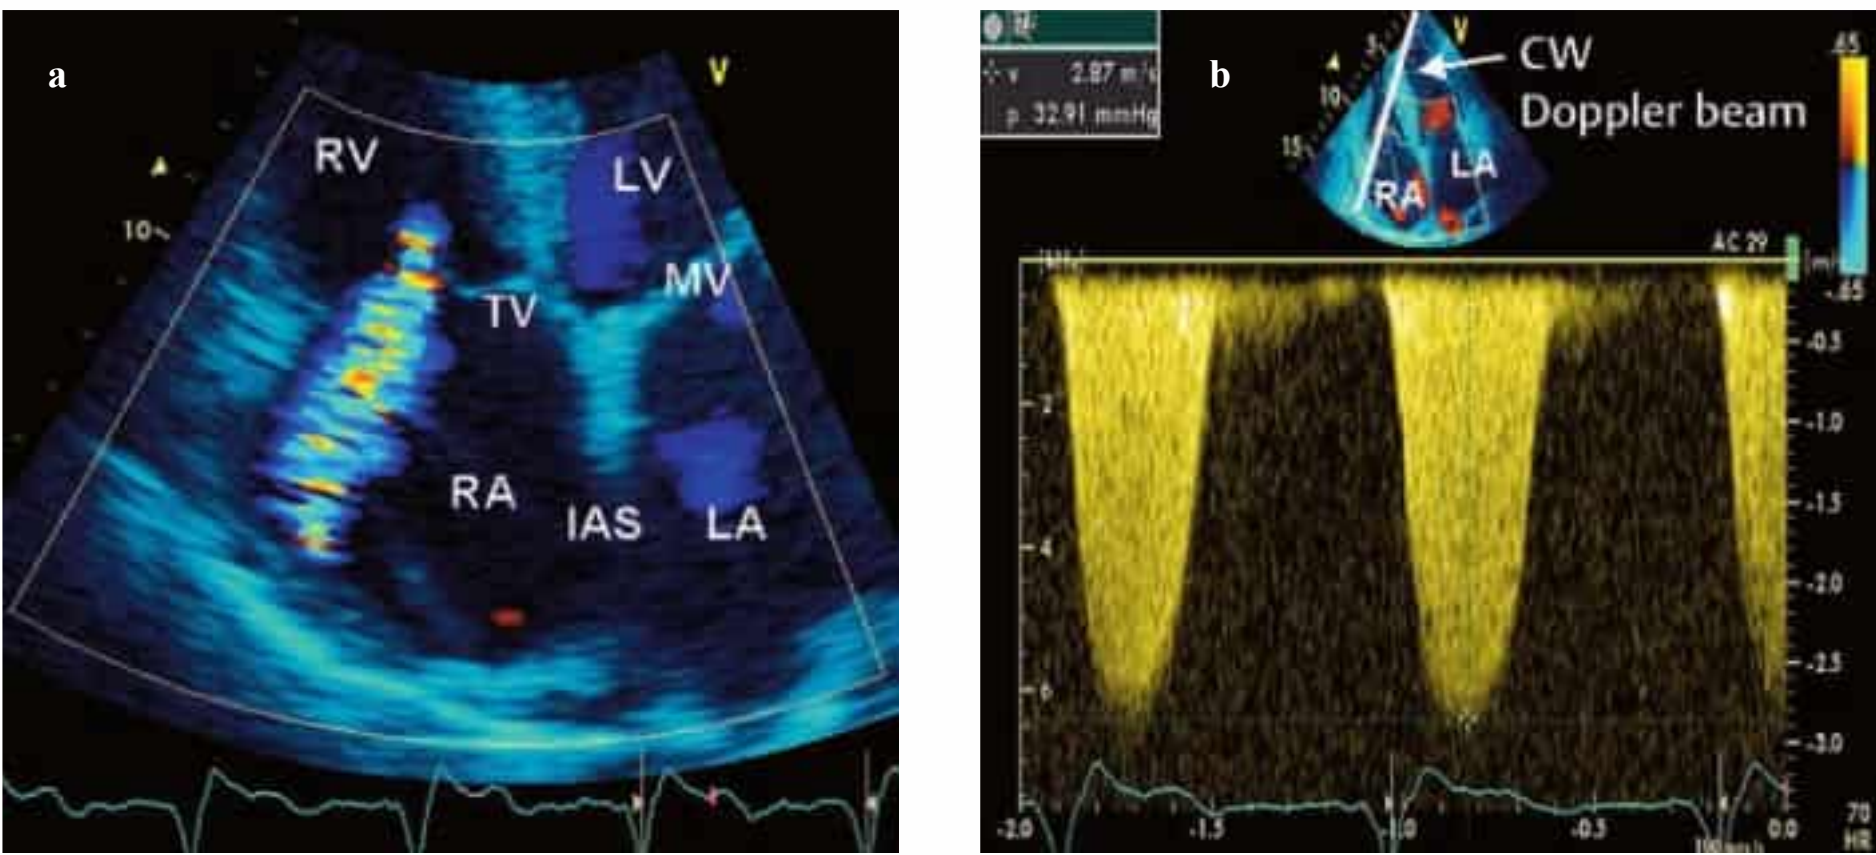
a, b CW Doppler imaging of the tricuspid valve (TV). The pressure gradient is calculated from maximum flow velocity. With the addition of right atrial pressure (RA), the systolic ventricular pressure of the RV is determined. In the absence of pulmonary stenosis (very rare), the systolic pulmonary arterial pressure CPAs can be determined with this formula: TV gradient 33 mmHg + RA = PAs .
